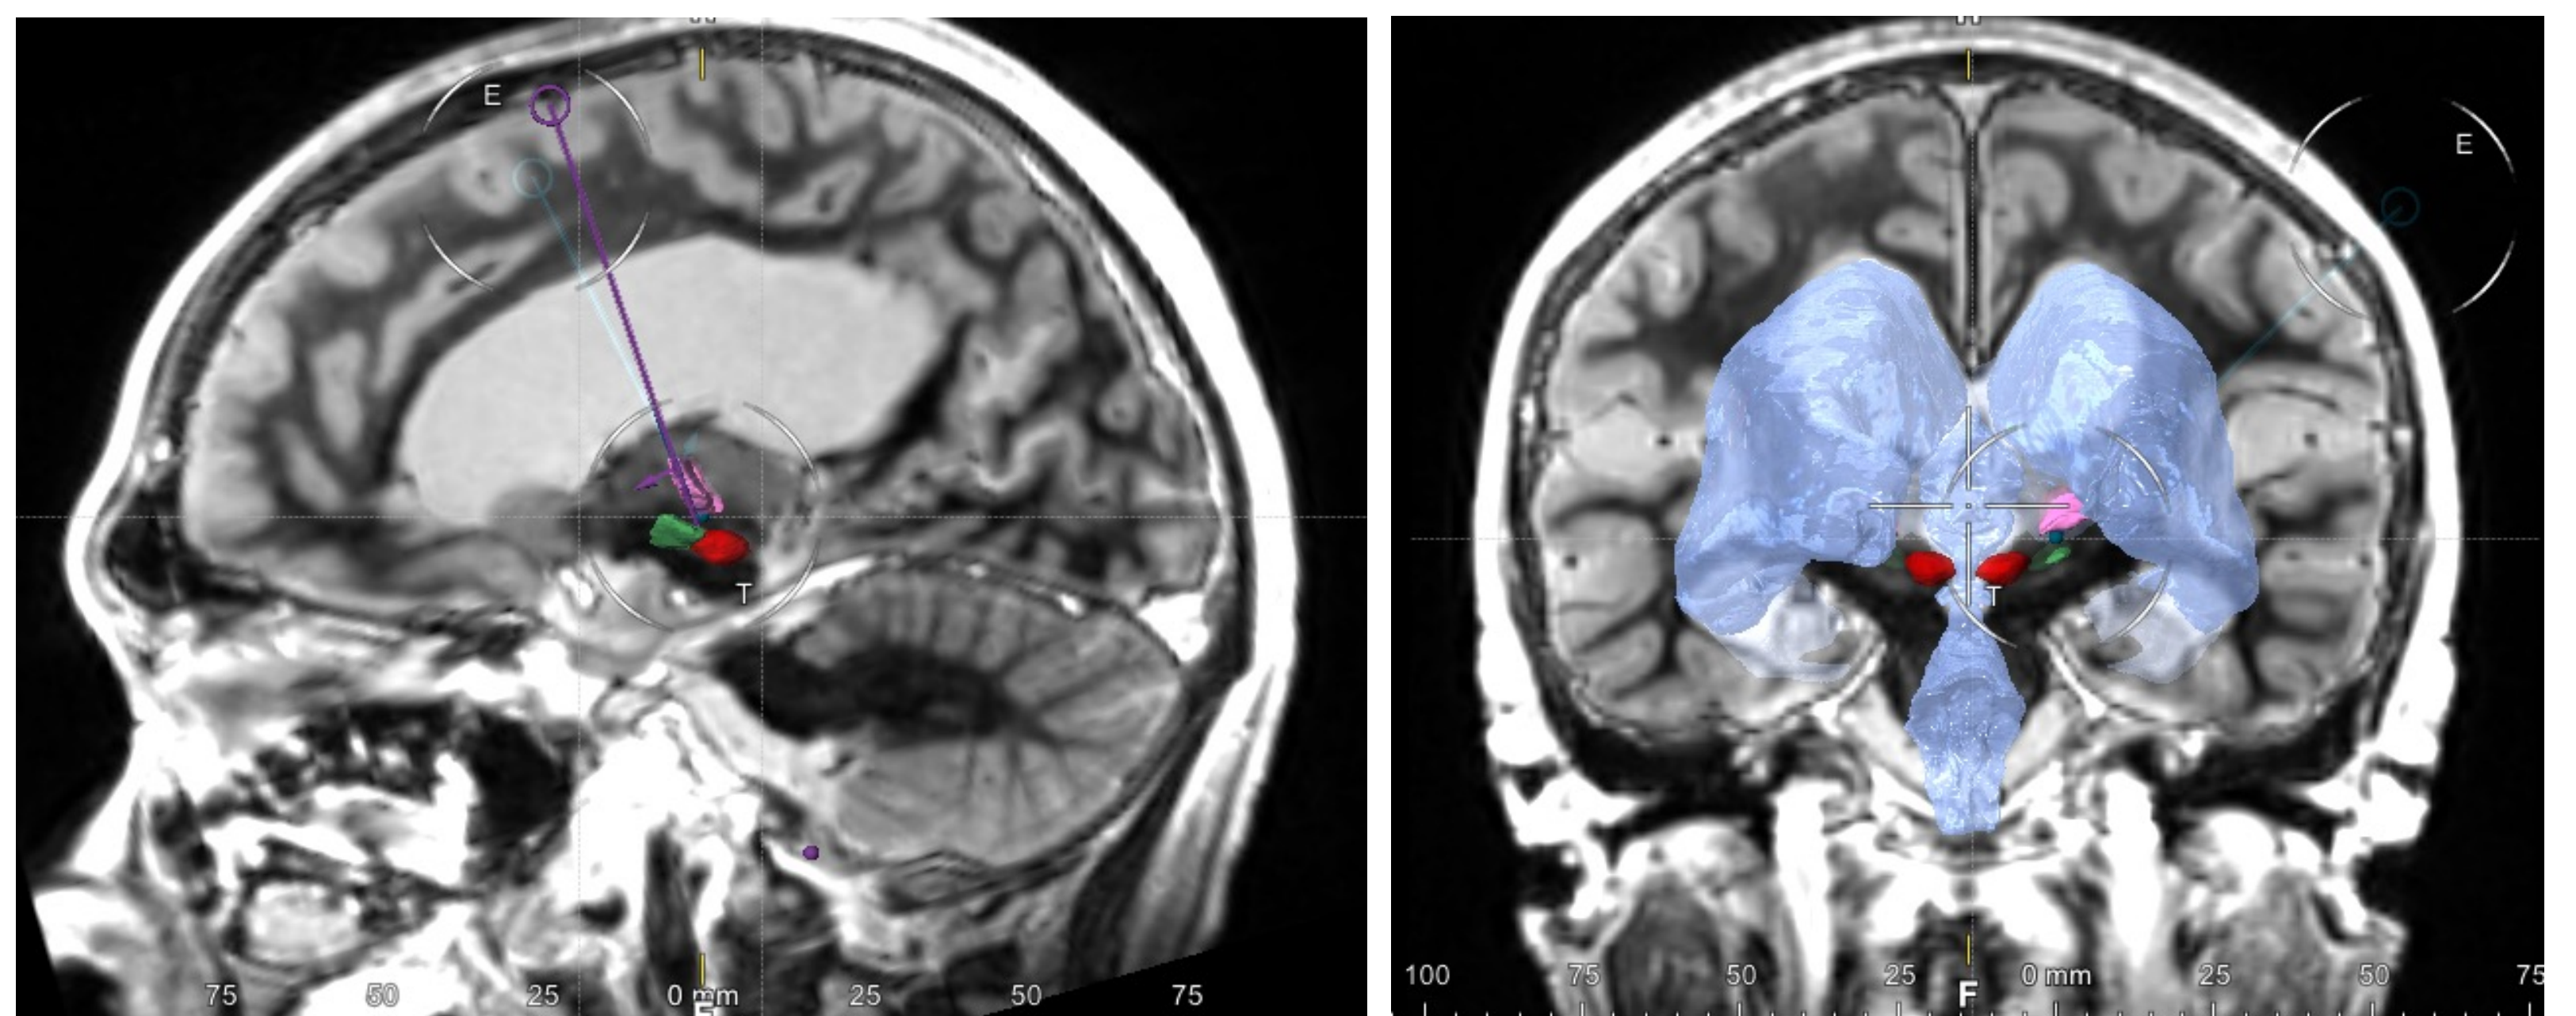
Pre-operative planning of the trajectory as depicted in sagittal and coronal FGATIR MRI
